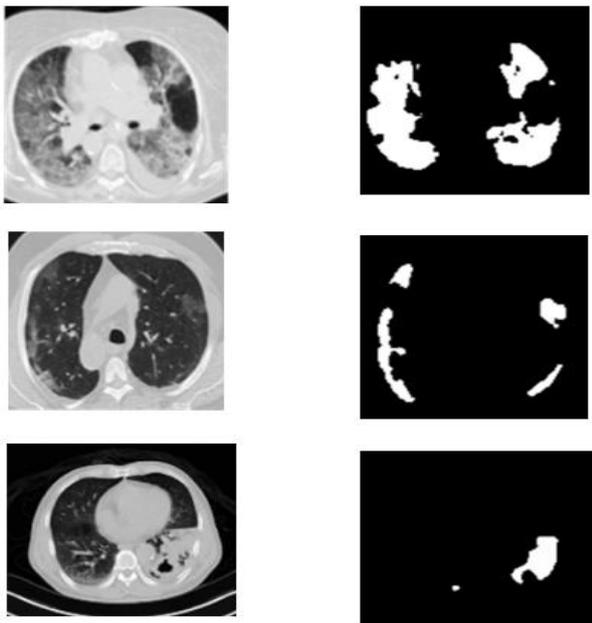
CT scan image of the lung.
